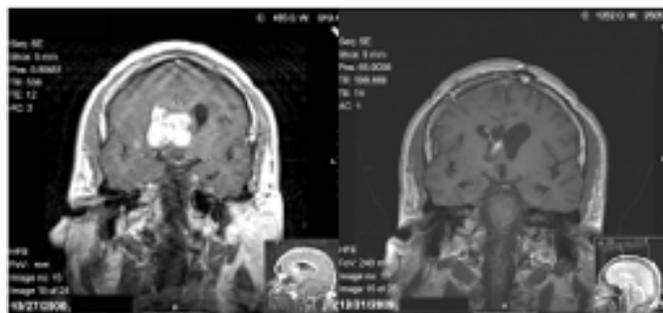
Left (a): GBM at first presentation in 2008. Right (b). Coronal MRI brain with Gadolinium 14 months after primary tumor resection shows some residual uptake in the primary tumor field. Of concern was the possibility that this lesion could potentially be tumor recurrence.
